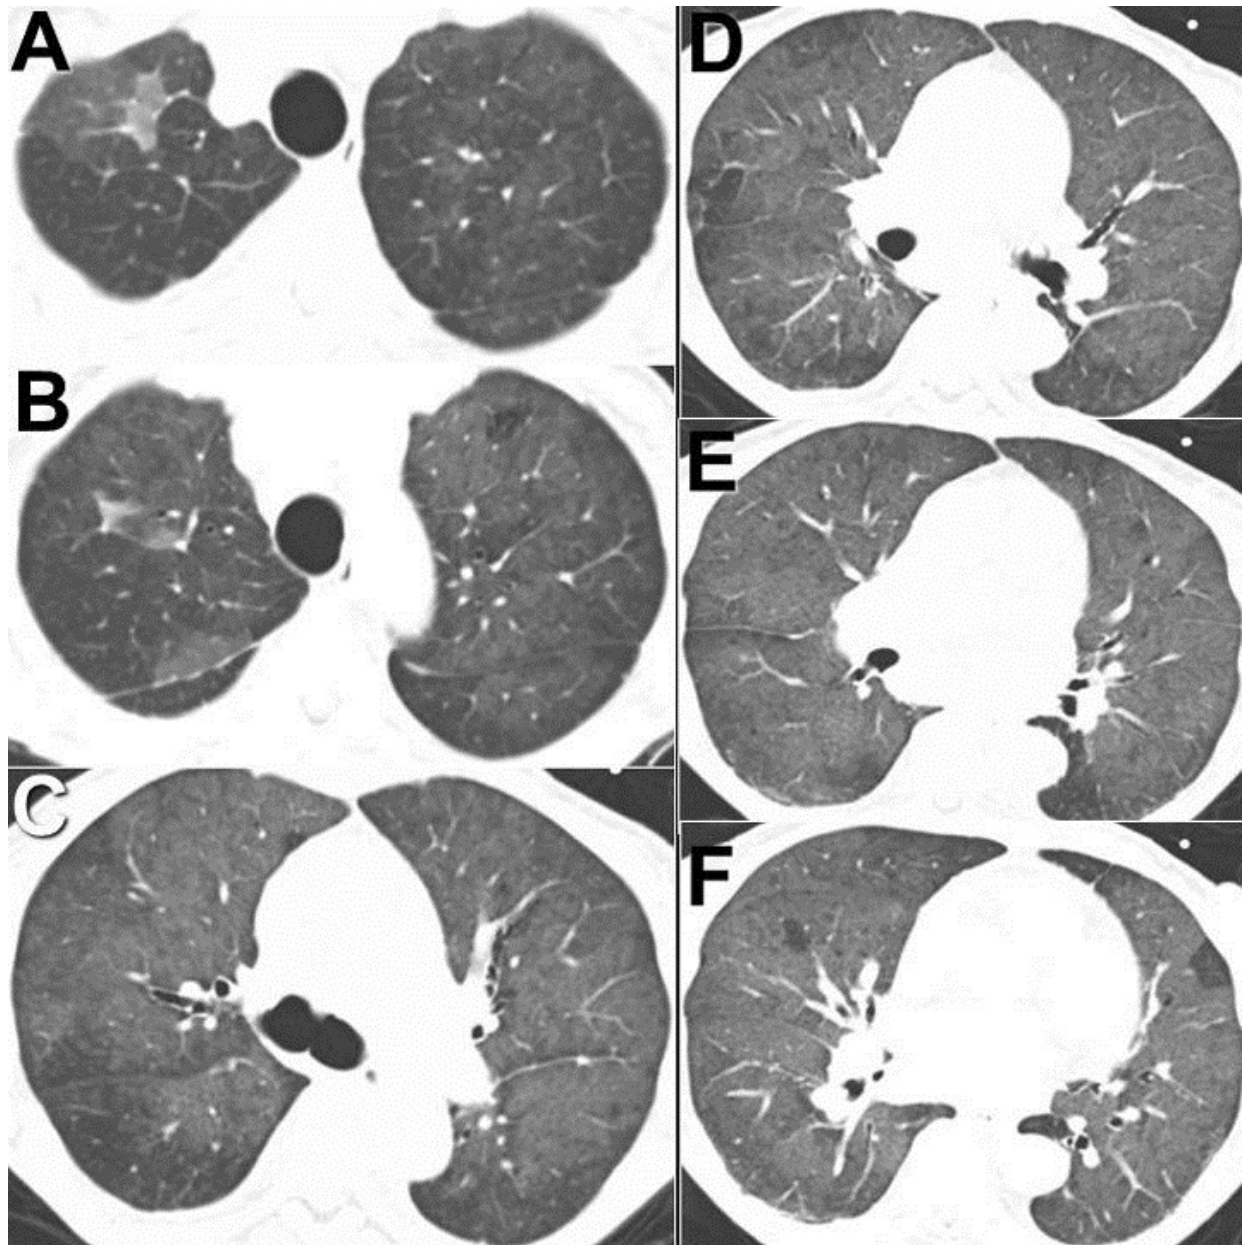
Thoracic CT scan displayed in lung windows.
